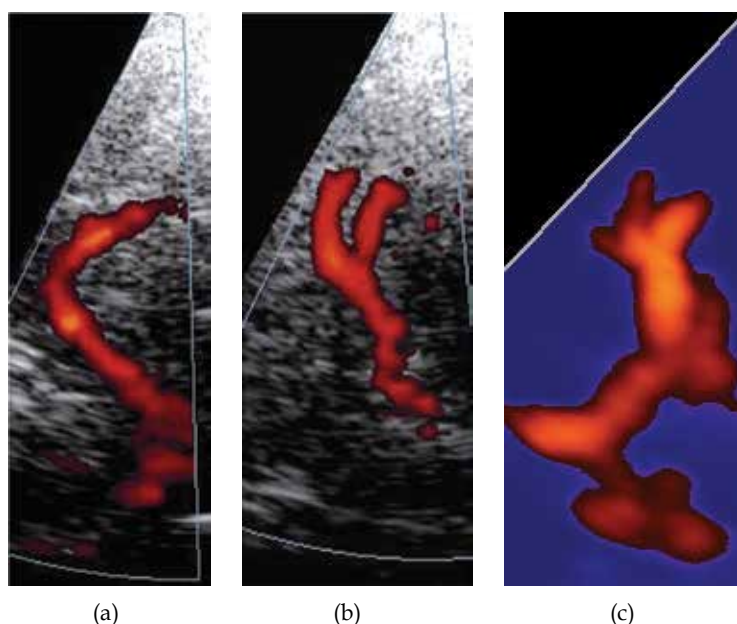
TCCS using power-Doppler showing the division patterns of the M1 segment: (a) monopode, (b) bipode and (c) tripode
